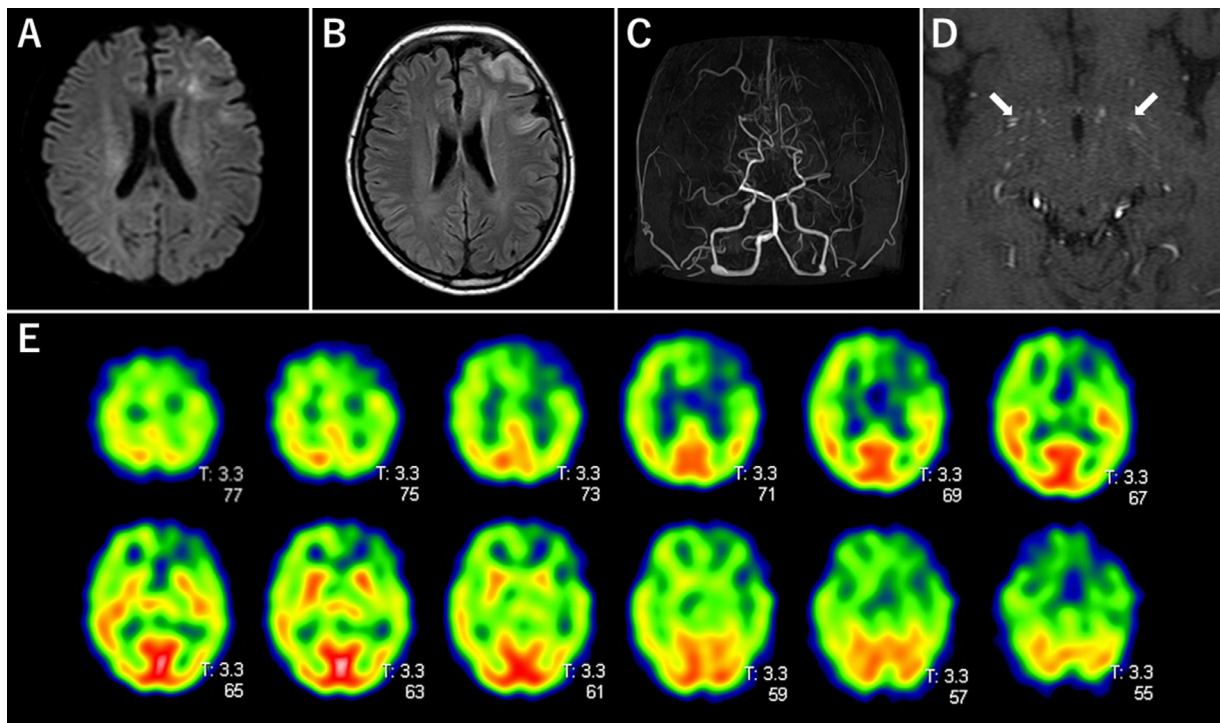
(A, B) Diffusion-weighted magnetic resonance imaging and fluid-attenuated inversion recovery imaging revealing high-intensity lesions in the left frontal lobe. (C, D) Magnetic resonance angiography showing occlusions of bilateral distal internal carotid arteries and abnormal vascular network in the basal ganglia (arrow). (E) Brain single-photon emission computed tomography revealing left-sided dominant hypoperfusion of bilateral frontal lobes.
